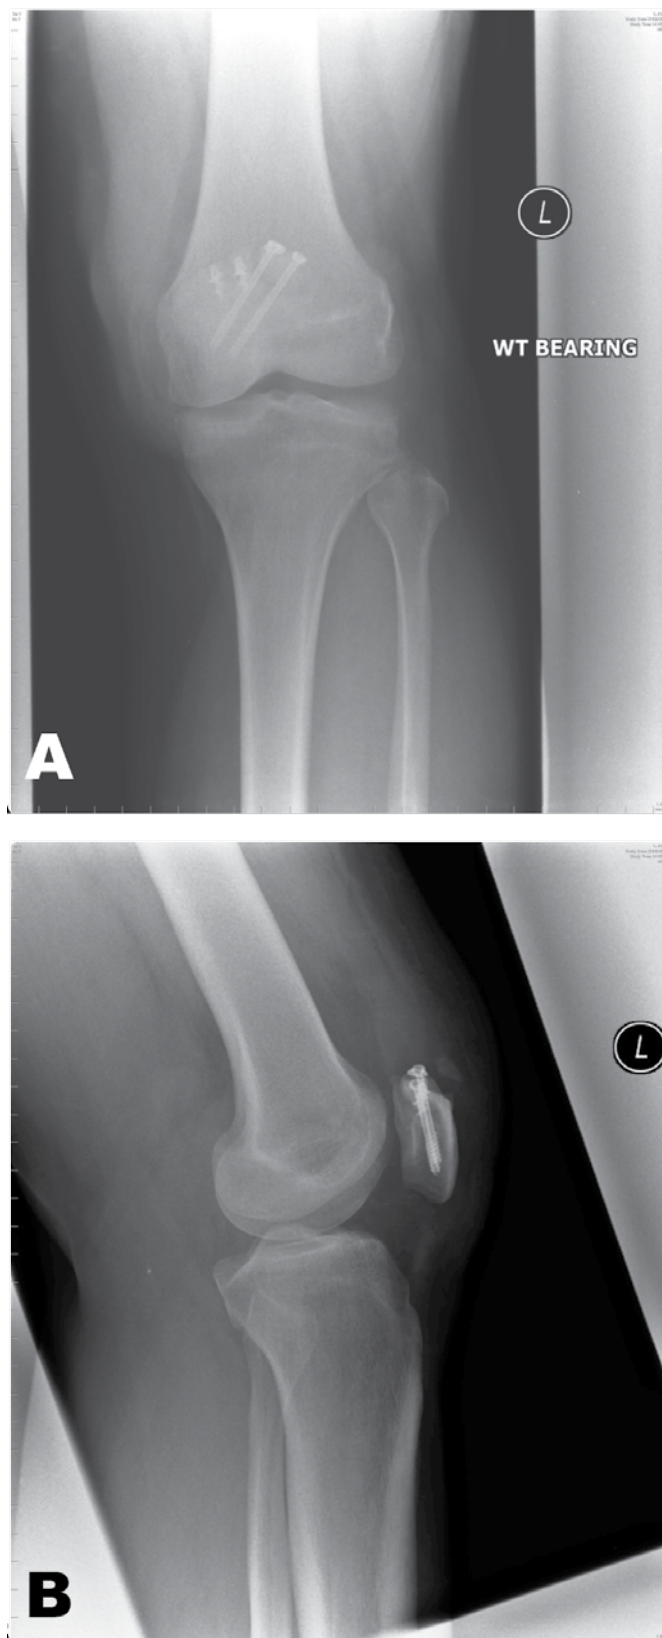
(A) Anterior-posterior radiograph of left knee postoperatively showing satisfactory reduction and screw fixation of the separation as well as anchors to reattach the quadriceps tendon. (B) Lateral radiograph of the left knee postoperatively.
